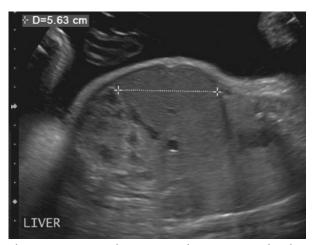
Hepatomegaly seen on ultrasonogram of a fetus with congenital syphilis infection. *Adhikari. Syphilis in Pregnancy. Obstet Gynecol 2020.*
